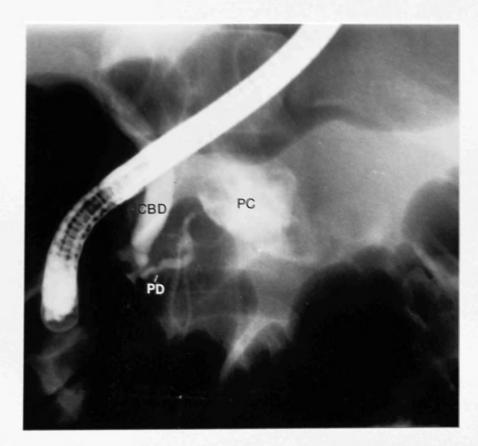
Radiograph taken during an ERCP. Contrast is seen leaking from the pancreatic duct into a large cavity.
